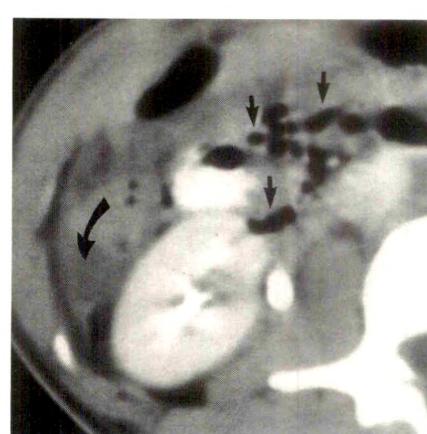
Surgically proved bowel necrosis resulting from blunt abdominal trauma. Contrast-enhanced CT scan shows dilated loops of bowel with poor definition of bowel wall and pneumatisis (straight arrow). Note associated mesenteric infiltration (open arrows) and free fluid in paracolic gutter (curved arrow).
